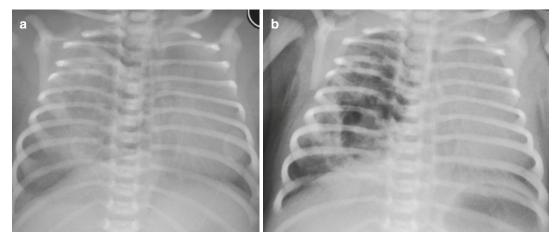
Congenital cystic adenomatoid malformation (CCAM). (a) Radiograph taken shortly after birth in a neonate with respiratory distress shows ill defined slightly heterogenous density occupying a large proportion of the right hemithorax. There is evidence of contra-lateral
